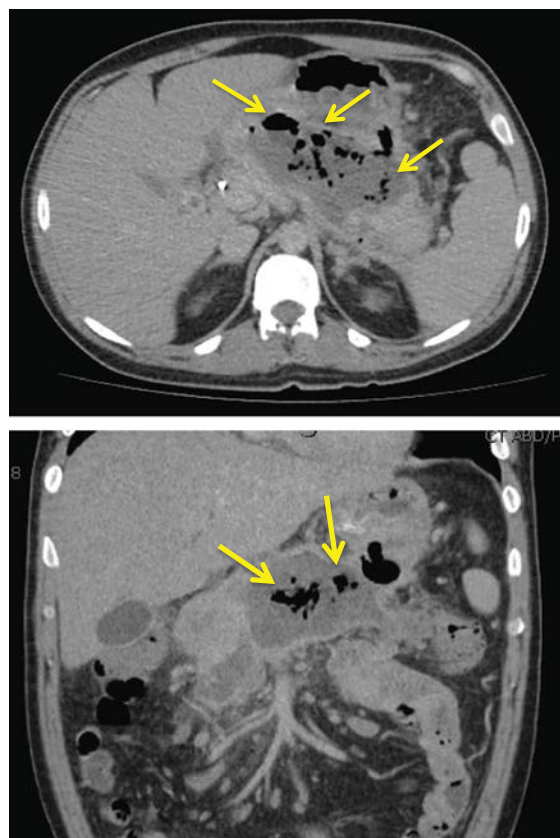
CT scan image (axial and coronal views) of infected WON with the presence of gas within the collection (yellow arrows).
